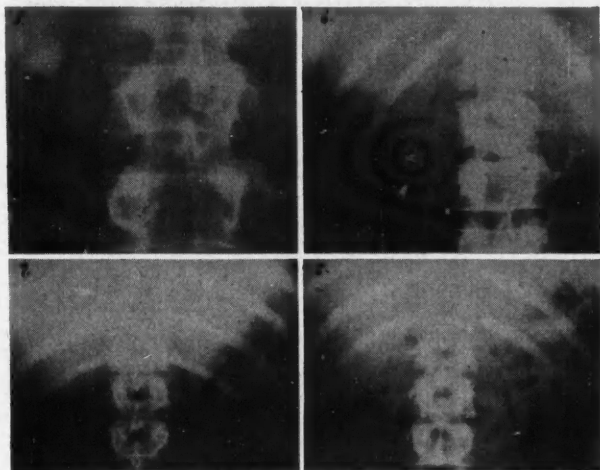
(Case 3).—X-ray of the lumbar spine less than 4 months after initial injury reveals an opacity filling the pelvis and calyces of the right kidney. Fig. 6. (Case 3).—X-ray less than a month after Fig. 5, following routine treatment shows complete disappearance of the shadow. A calculus is shown in the left ureter at the level of the 4th lumbar transverse process. Fig. 7. (Case 4).—X-ray 2 weeks after initial injury reveals an opaque shadow filling the calyces of the left kidney. Fig. 8. (Case 4).—X-ray after routine care including pelvic lavage reveals disappearance of the shadow with persistence of a small residual opacity.
